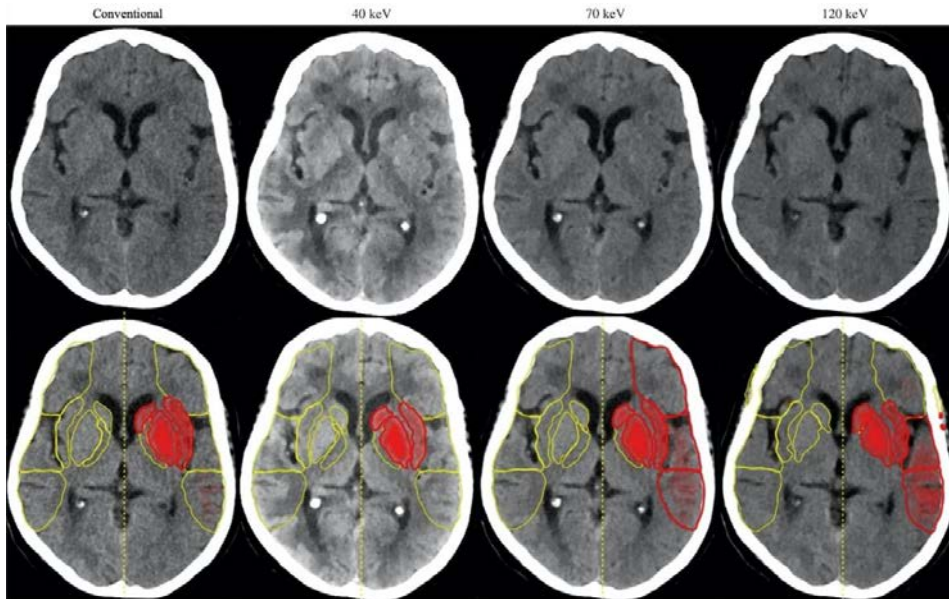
An example of axial image slices for conventional and VMI 40, 70 and 120 keV (from left to right) reconstructions. The second row shows the automated ASPECTS detection result, where red indicates an area with early ischemic changes. This patient had nine regions with early ischemic changes according to the refASPECTS (all except region M4), whereas the automated ASPECTS algorithm identified four regions in the conventional images, three in VMI 40 keV, eight in VMI 70 keV and eight in VMI 120 keV. refASPECTS = reference standard ASPECTS.
